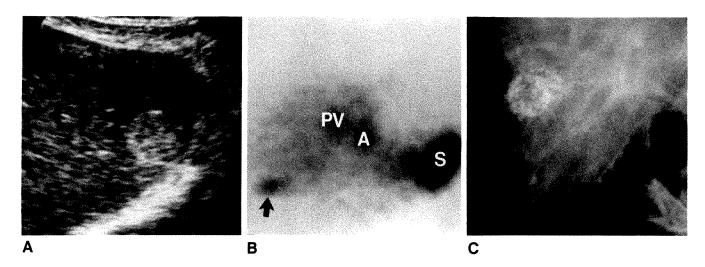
Typical sonographic appearance of hemangioma in patient at high risk for hepatocellular carcinoma.
